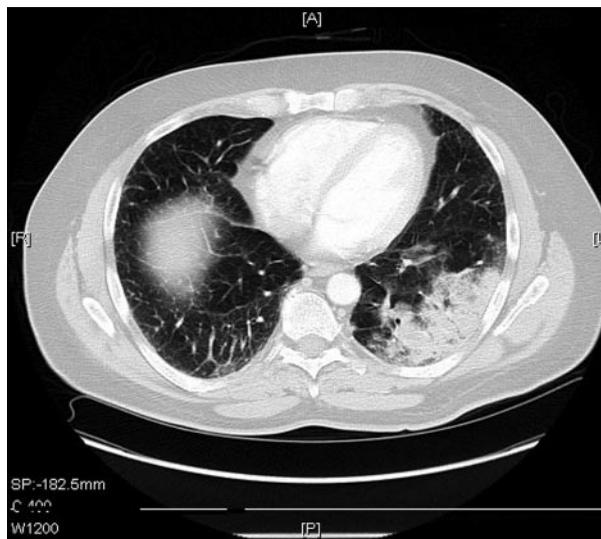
A contrast-enhanced computed tomography angiogram of the chest showed consolidation in the left lower lobe.
